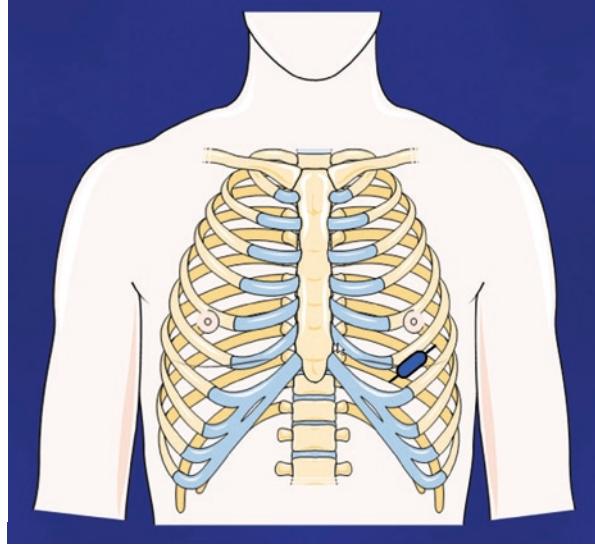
Apical 4 Chamber (4C) view. All four cardiac chambers are visualized in the 4C view along with the mitral and tricuspid valves. Ventricular and atrial size can be assessed using 2D echo. Color flow and spectral Doppler can be used to assess for valvular regurgitation and stenosis. Left ventricular diastolic function can be assessed using pulsed wave Doppler of the mitral valve and pulmonary veins. In this view, the right ventricular freewall, interventricular septum, and left lateral wall can be assessed for systolic motion
